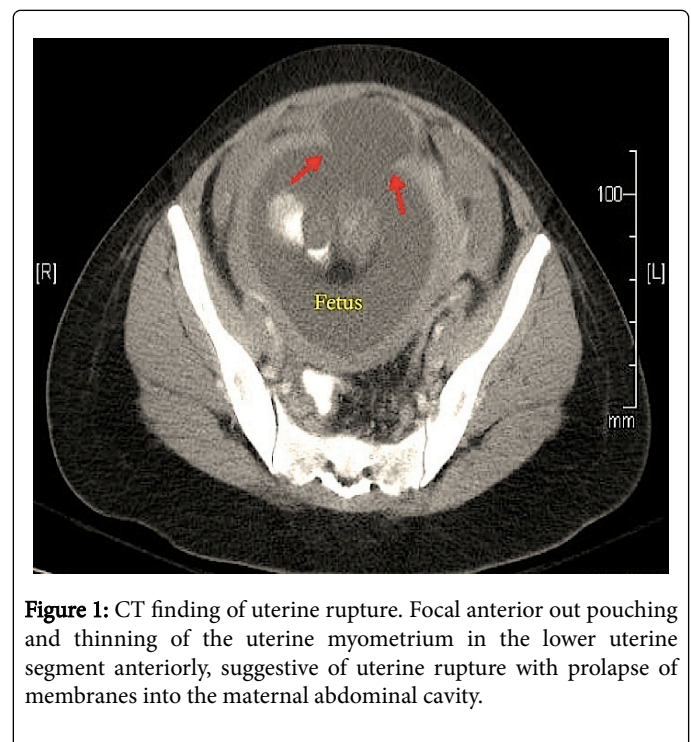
CT finding of uterine rupture. Focal anterior out pouching and thinning of the uterine myometrium in the lower uterine segment anteriorly, suggestive of uterine rupture with prolapse of membranes into the maternal abdominal cavity.
